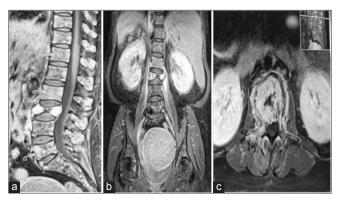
(a-c) Case 2 – Preoperative sagittal, coronal, and axial magnetic resonance imaging of the lumbar spine revealed severe compression collapse fracture of the L3 vertebral body with T2 marrow hyperintensities and mild retropulsion of the fracture fragments with thecal sac compression.
